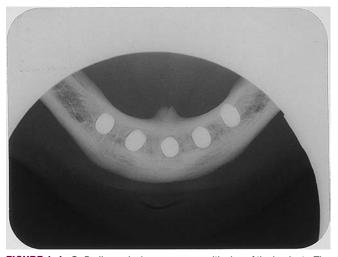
C, Radiograph shows proper positioning of the implants. The most posterior implants are approximately 5 mm anterior to the mental foramen. Note the 3-mm spaces between the bodies of the implants.
